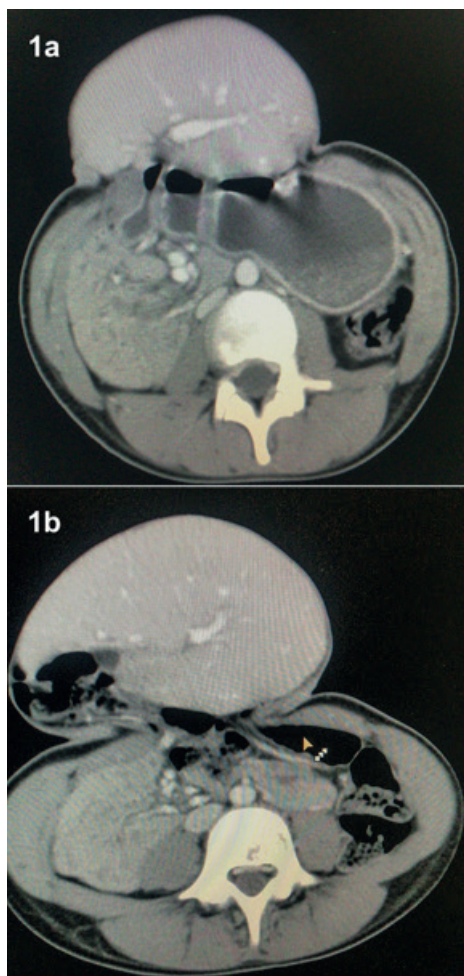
(a and b). CT scan abdomen and pelvis (with contrast). Malrotated gut: the findings are likely gastrochisis with bilobed liver; one lobe is in the herniated sac subcutaneously and the other lobe is in the abdominal cavity.
